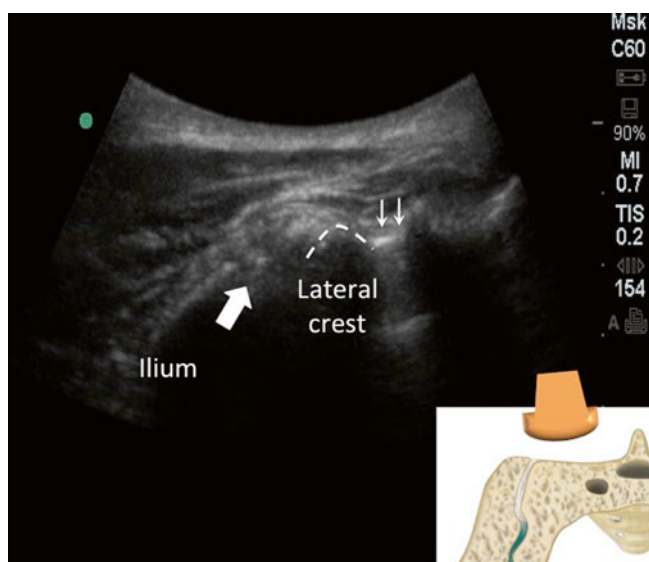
Sonography of the lower sacroiliac joint (SIJ). The probe position was indicated in the *insert* in the *lower right corner*. The SIJ was indicated by the bold arrow, which is typically lateral to the lateral crest. Note the flat appearance of the ilium. The S2 foramen was indicated by the *line arrows* (Reproduced with permission of Philip Peng Educational Series)
